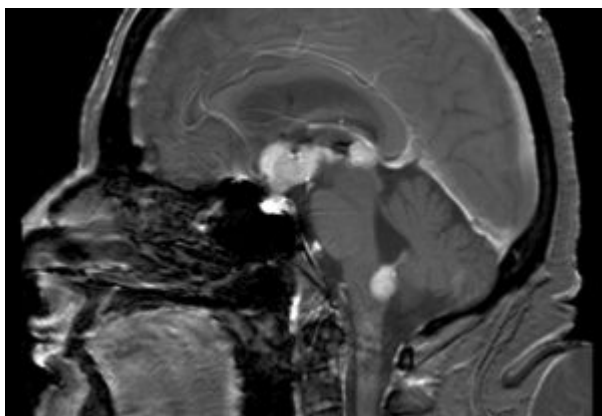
"Brain MRI showing primary central nervous system B-cell non-Hodgkin lymphoma of the sella turcica and hypothalamus, continuing to the tectum." by Steven Fruitsmaak - Own work.
